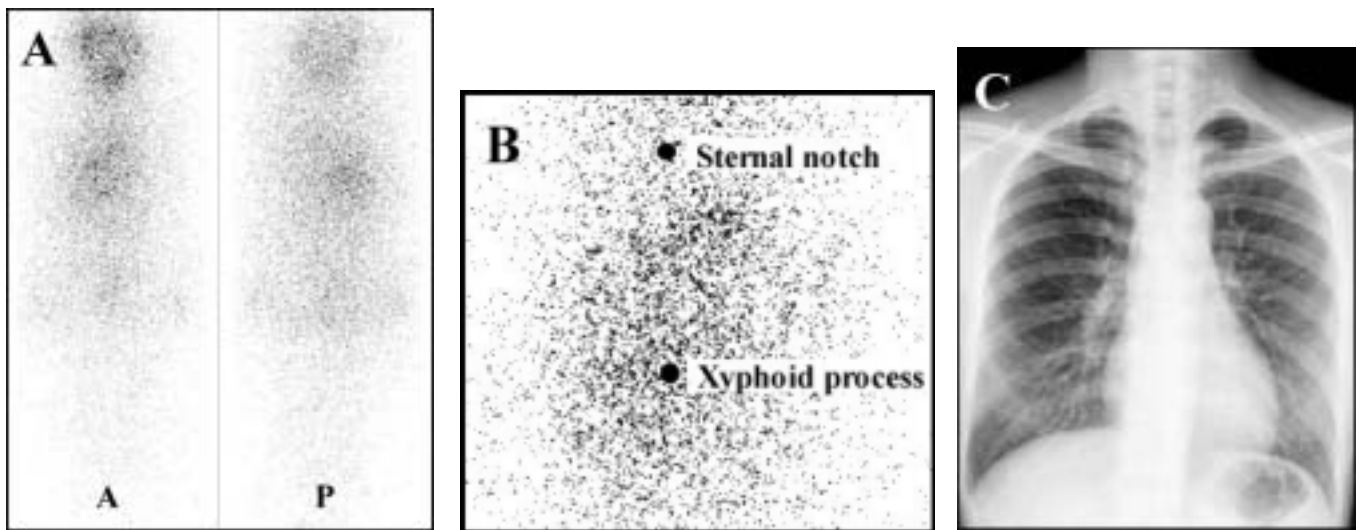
^{131}I scan: (A) whole-body image, (B) focal view showed faintly increased uptake in the right lower lung field. (C) Chest X-ray revealed reticular lung marking in the corresponding lower right lung field.
